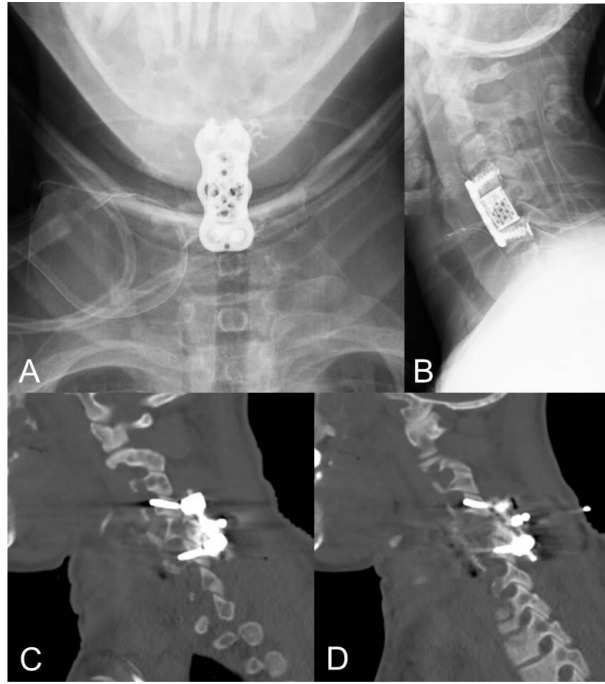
Post-operative imaging. A, anteroposterior and B, lateral plain radiographs following stage 1 procedure (C5 corpectomy, cage insertion with autologous bone from iliac crest, cement augmentation of C4 and C6 vertebral bodies and plate and screw insertion). C, right parasagittal and D, left parasagittal slices of CT scan following stage 2 procedure (posterior decompression with C4-6 lateral mass screws).
